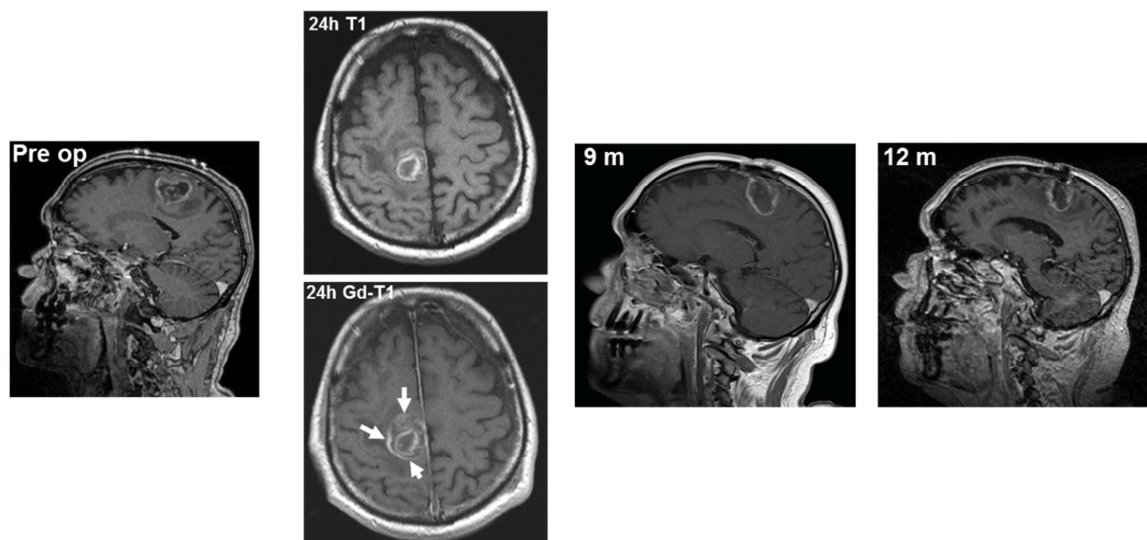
T1-weighted imaging studies of a patient with residual tumor after IORT. This patient is a 63 year old male presenting with a right frontal lobe GBM (methylated MGMT promoter). Multiple areas with residual tumor (white arrows) were seen in a postoperative T1-MRI scan without (upper) and with (lower) contrast. Despite considerable amounts of residual tumor after surgery and IORT, there is no recurrence within 12 months.
